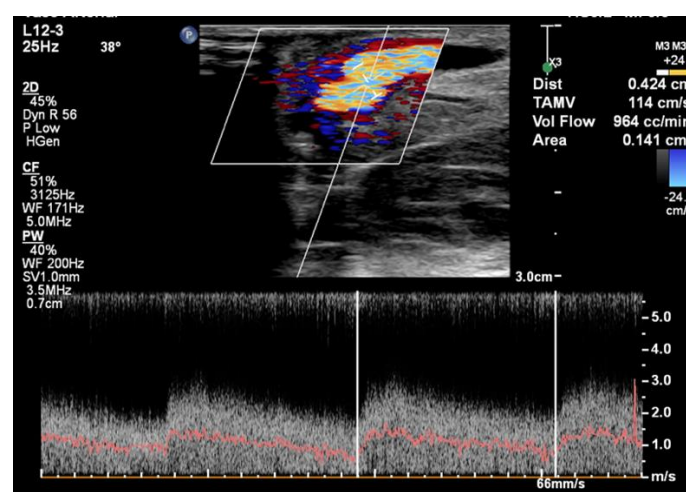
Colour Doppler ultrasound image depicting the flow volume (ml/min) of the venous component
